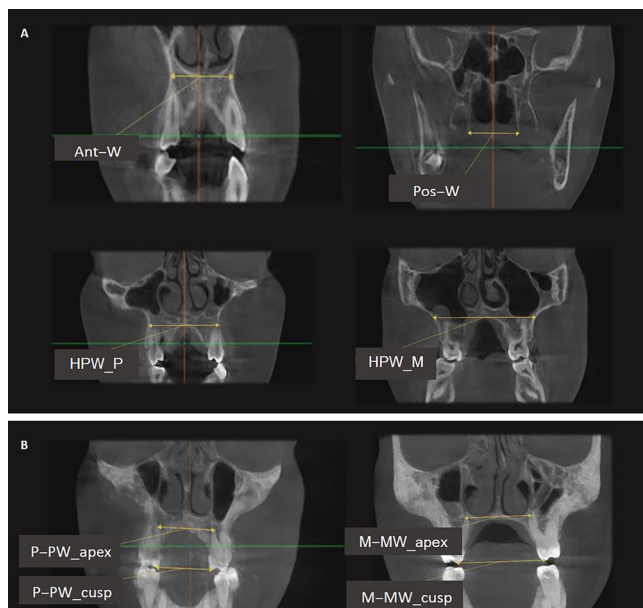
Measurements determined on cone-beam computed tomography (CBCT) images
